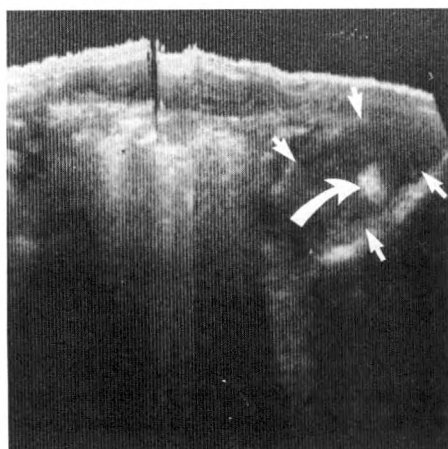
Iliopsoas hematoma. Transverse sonogram of pelvis shows thickening of left iliopsoas muscle (short arrows) and lateral displacement of femoral nerve complex (curved arrow).
